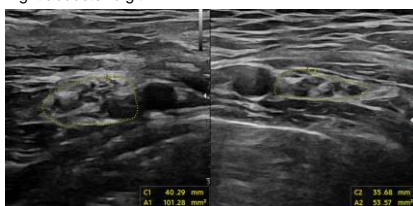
Sonographic examination revealed swelling of right brachial plexus, just below clavicle level
